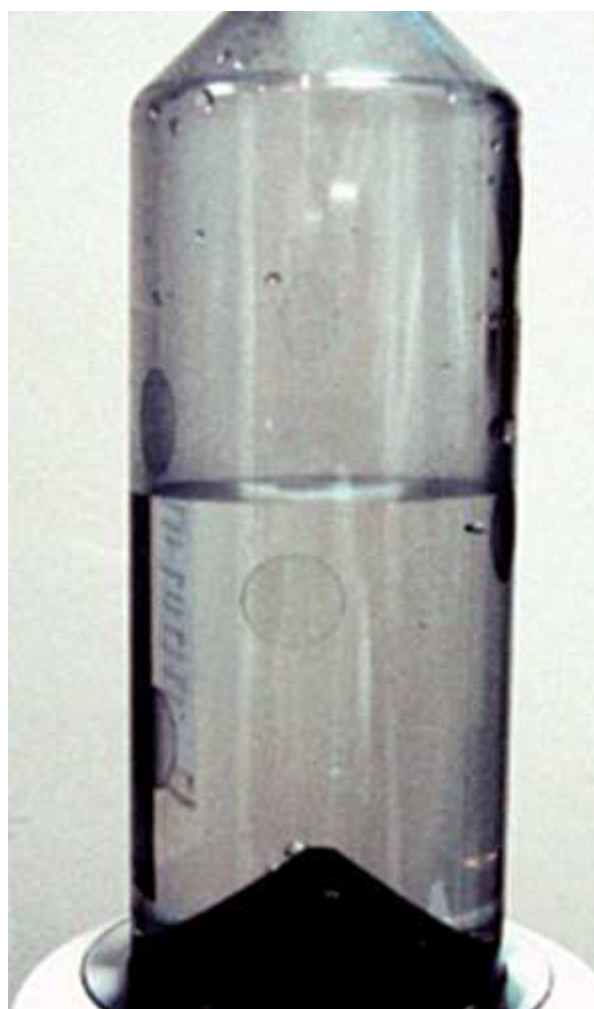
CT pressure syringe partially filled with contrast material. Note oval etching above fluid level and round etching below fluid level.
